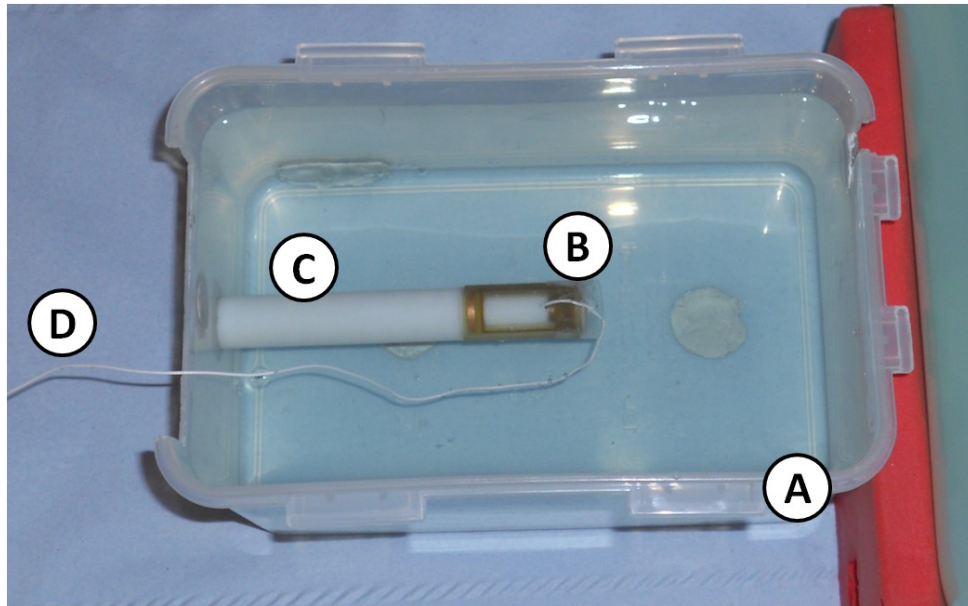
Experimental setup, showing (a) plastic container filled with liquid, (b) duodenoscope tip coil, (c) plastic mandrel to rigidly mount the tip coil and (d) coil connection to MRI scanner.
